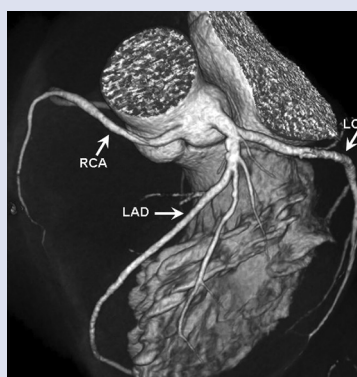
Three-dimensional reconstruction from the CT imaging; LAD — left anterior descending artery; LCX — left circumflex artery; RCA — right coronary artery
